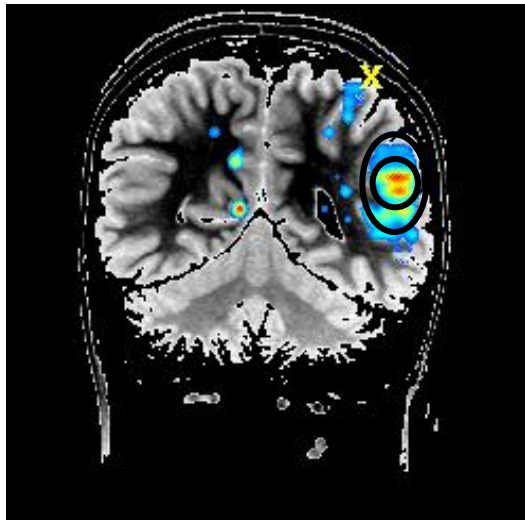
MRI Coronal slice with 2DII source localization of an interictal spike. Inner circle surrounds area of most intense cortical activity, outer circle encompasses moderate neuronal activity. Slice thickness 1.5mm. Gray scale is light for gray matter.
